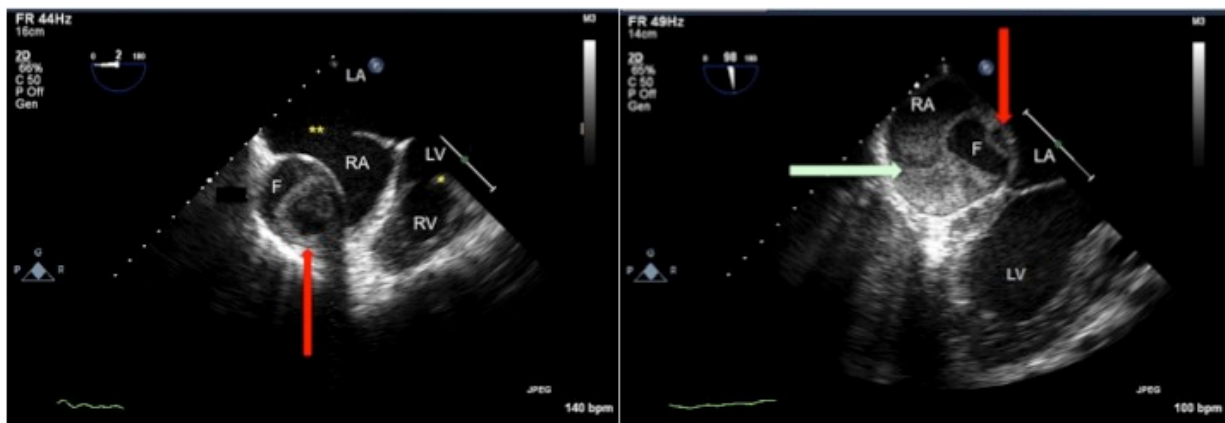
Transesophageal echocardiography, showing the right atrium (RA), left atrium (LA), right ventricle (RV), left ventricle (LV), atrial septal defect (), ventricular septal defect (*), Fontan lateral tunnel (F), mural thrombus in lateral tunnel (red arrow), and stasis in right atrium (green arrow).
